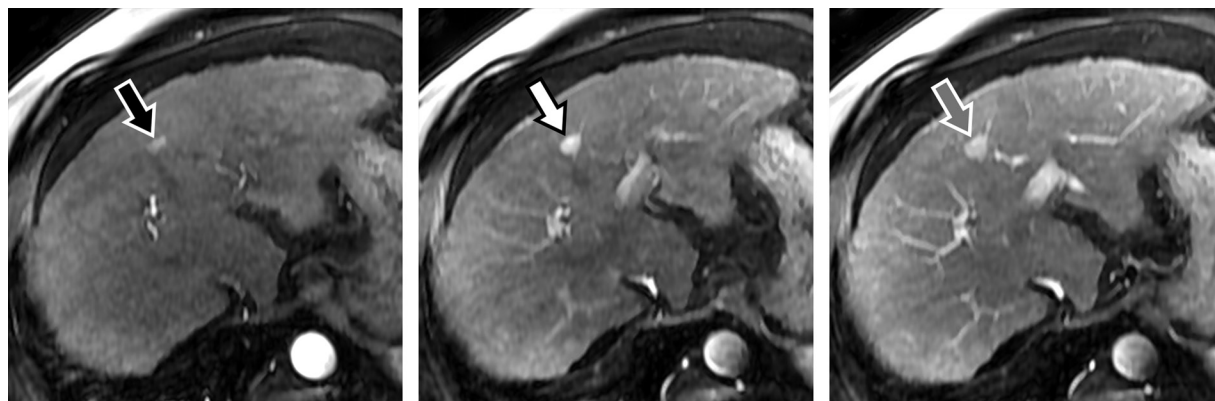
Inaccurate lesion size estimation during arterial phase MR imaging in a 60-year-old man with HCC categorized as LR-4 (probably HCC) on the basis of major and ancillary imaging features. Axial early arterial phase (a), midarterial phase (b), late arterial phase (c), and hepatobiliary phase (d) MR images show a 9-mm (a), 12-mm (b), and 15-mm (c) nodule (arrow) during the arterial phases and an 11-mm nodule (arrowhead in d) during the hepatobiliary phase. Measurements should always be performed during the phase when the margins are most clearly visible and along the largest axis, as detailed in Figure 5. Measurement of lesion size during the arterial phase should be avoided.
